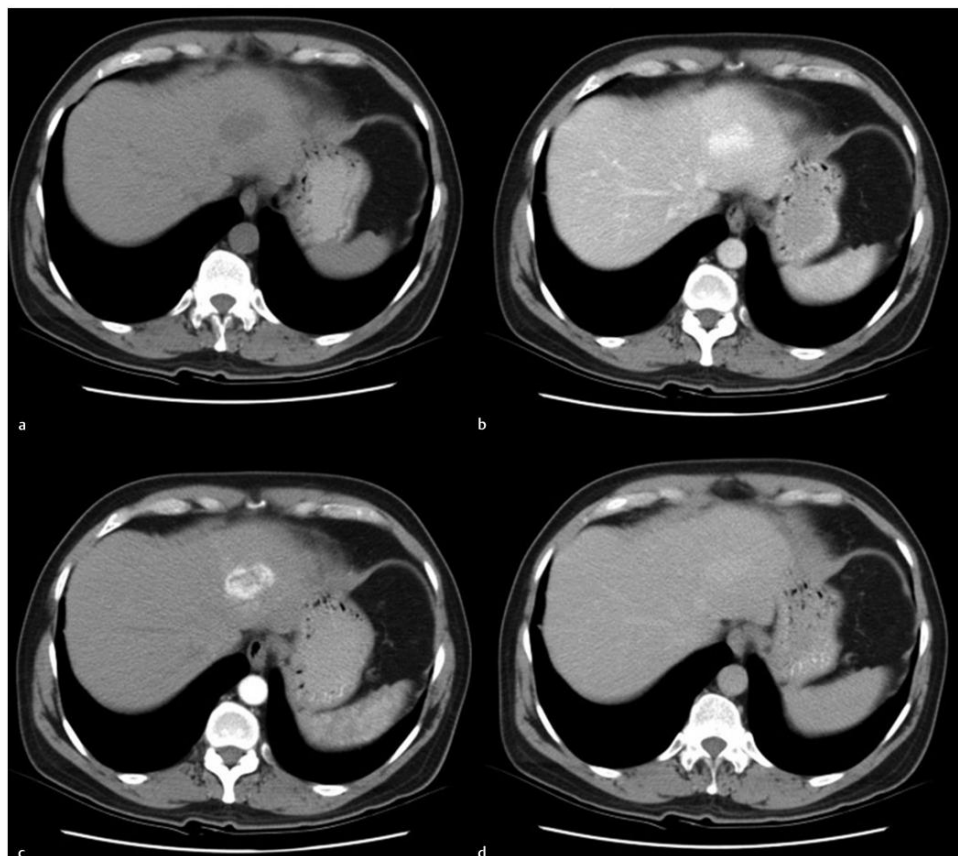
Unenhanced axial CT image (a) demonstrates a hypodense mass within the left lobe. The mass demonstrates peripheral nodular enhancement on arterial phase imaging with a central hypodense scar (b). On venous phase imaging (c), the mass is hyperdense to surrounding hepatic parenchyma. On delayed imaging (d), the lesion is isodense to the surrounding hepatic parenchyma.
